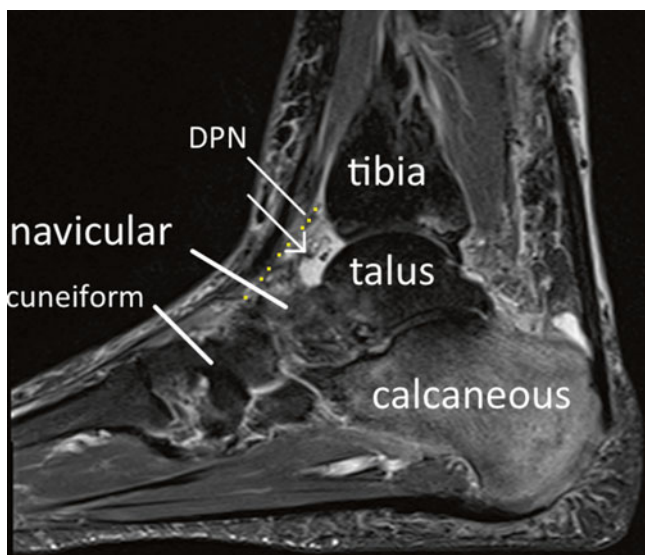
MRI T2 sagittal view of ankle; *arrow* shows anterior ganglion cyst (Image courtesy of Andrea Trescot, MD)
